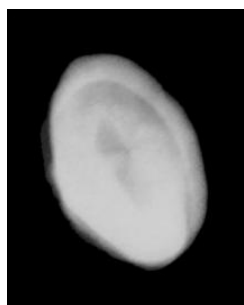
Radiograph of the maxillary right third molar transversally positioned.
